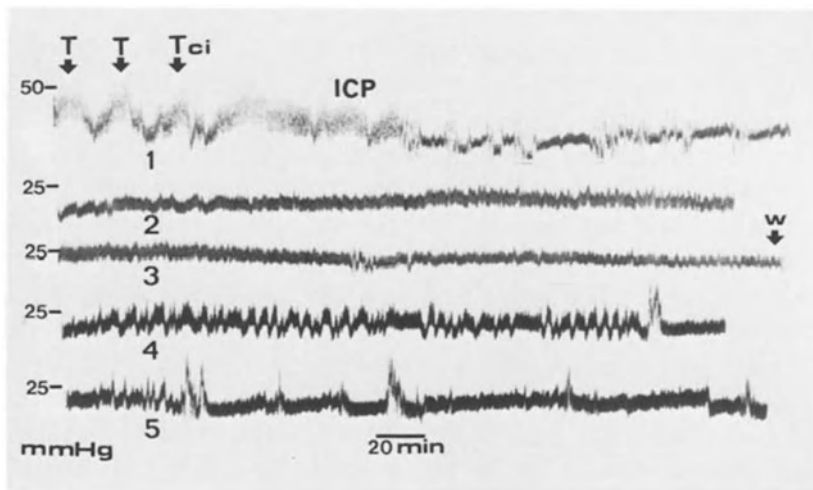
Intracranial pressure recording in a 16 year-old girl who was unconscious from the moment of the impact and showed generalized brain swelling on the admission CT scan. Initial ICP was 50 mmHg. A bolus of thiopental (*T*) decreased ICP for brief periods but continuous infusion of this drug (*T ci*) led to stabilization and definitive control of raised ICP. Four days after initiation of treatment, when the next CT scan showed decreased swelling, thiopental was withdrawn; ICP recording became unstable but ICP remained below 20 mmHg. The final outcome was good recovery
